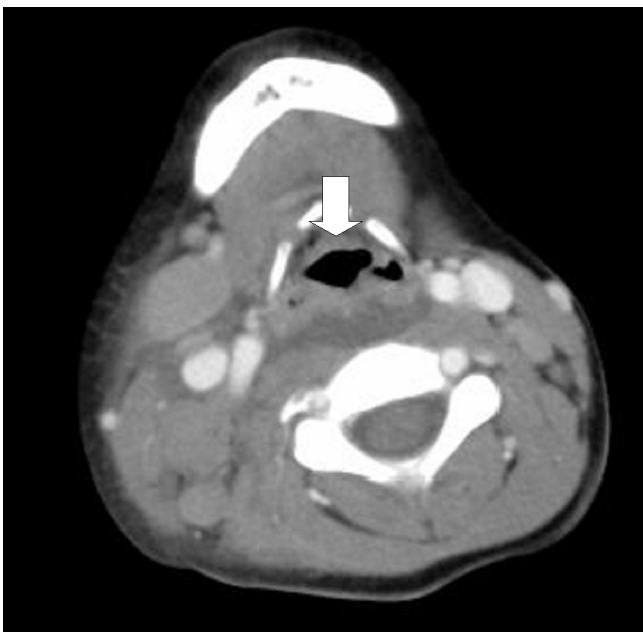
CT scan of neck demonstrating widening of the retropharyngeal space with a central hypodense lesion, suggestive of a retropharyngeal abscess.
